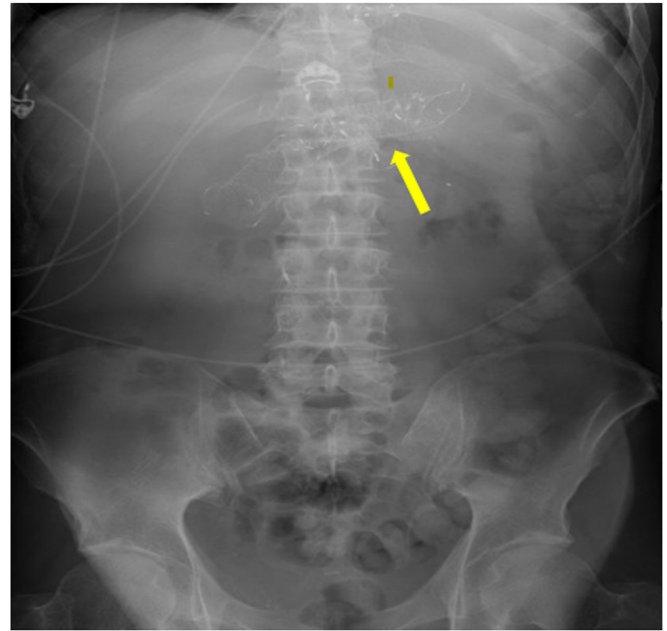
Abdominal x-ray 1 week after fully covered self-expandable metal stent placement confirms appropriate positioning of the stents from the gastroesophageal junction to the stomach (*tip of yellow arrow*).
